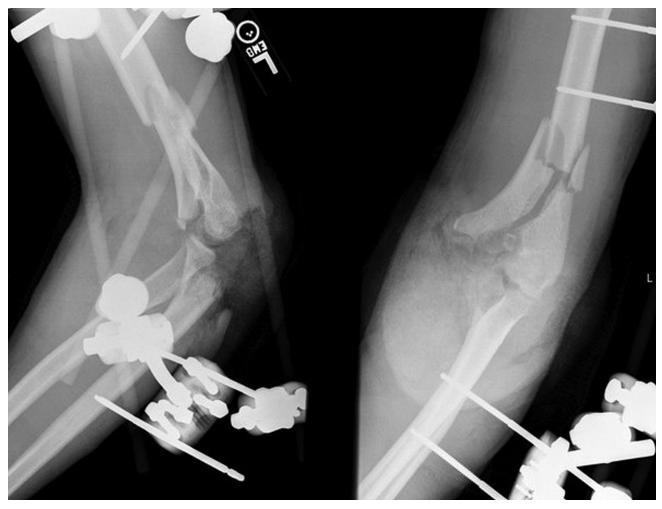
Radiograph of external fixation.
